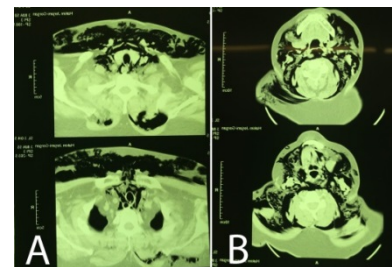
Neck and Thorax CT scan of the patient: A) Subcutaneous and mediastinal emphysema, B) Neck emphysema.
